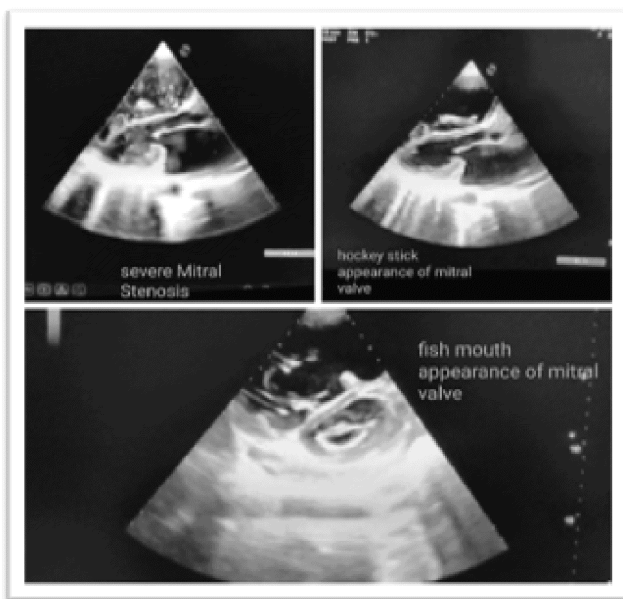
2d - echo showing signs of severe mitral stenosis ; (A) coloured doppler showing severely stenosed mitral valve B) classic hockey stick appearance of mitral valve C) Fish mouth shaped mitral valve suggesting Severe Mitral stenosis
